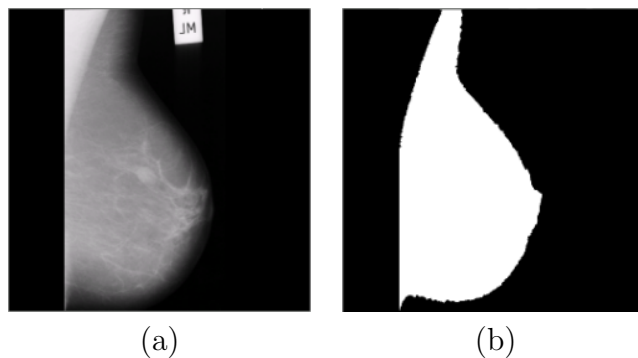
(a) X-ray mammogram and (b) breast profile segmentation.
